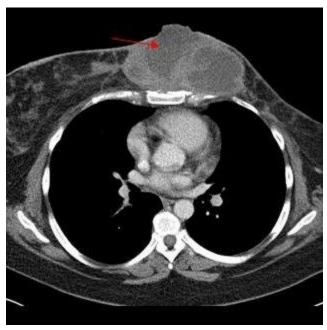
CT scan of Huge Progressive Breast Primary Phyllodes Tumor
